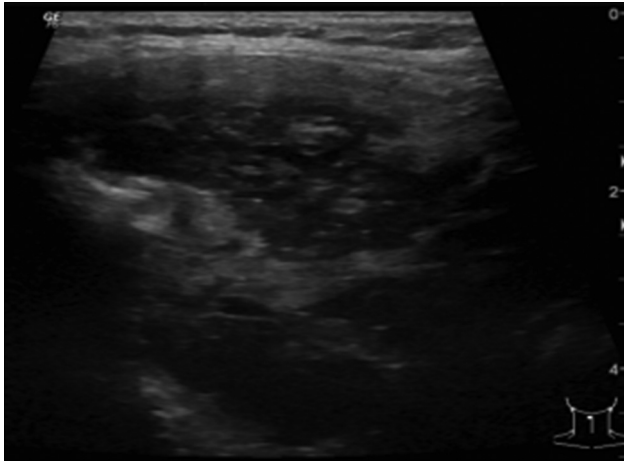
Cervical ultrasound: sub sternal goiter with heterogeneous echo structure. No enlarged lymph nodes.
